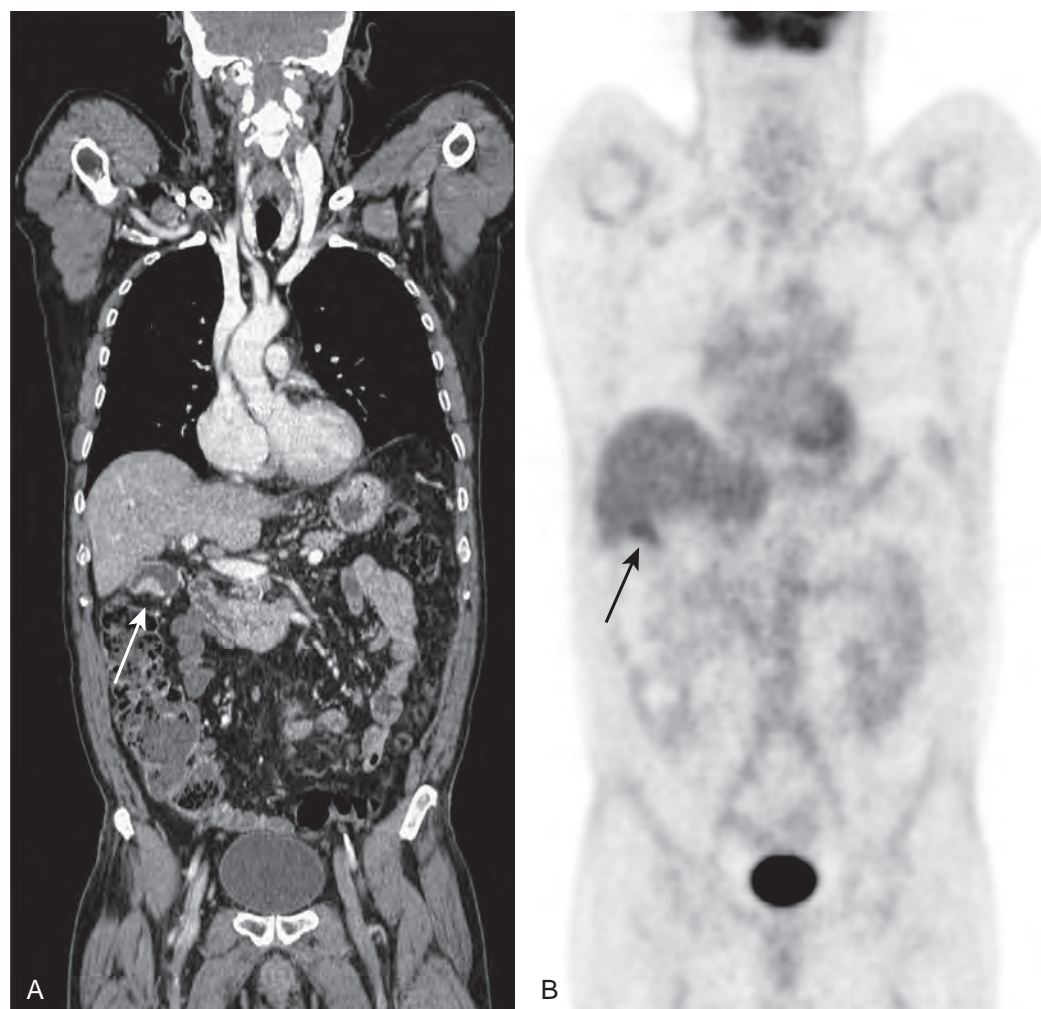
Gallbladder carcinoma. A. Contrast-enhanced CT demonstrates focal thickening of the inferior wall of the gallbladder (arrow). B. This region demonstrated increased FDG avidity on PET (arrow), without evidence of distant metastases. This was confirmed as gallbladder carcinoma on surgical resection.
